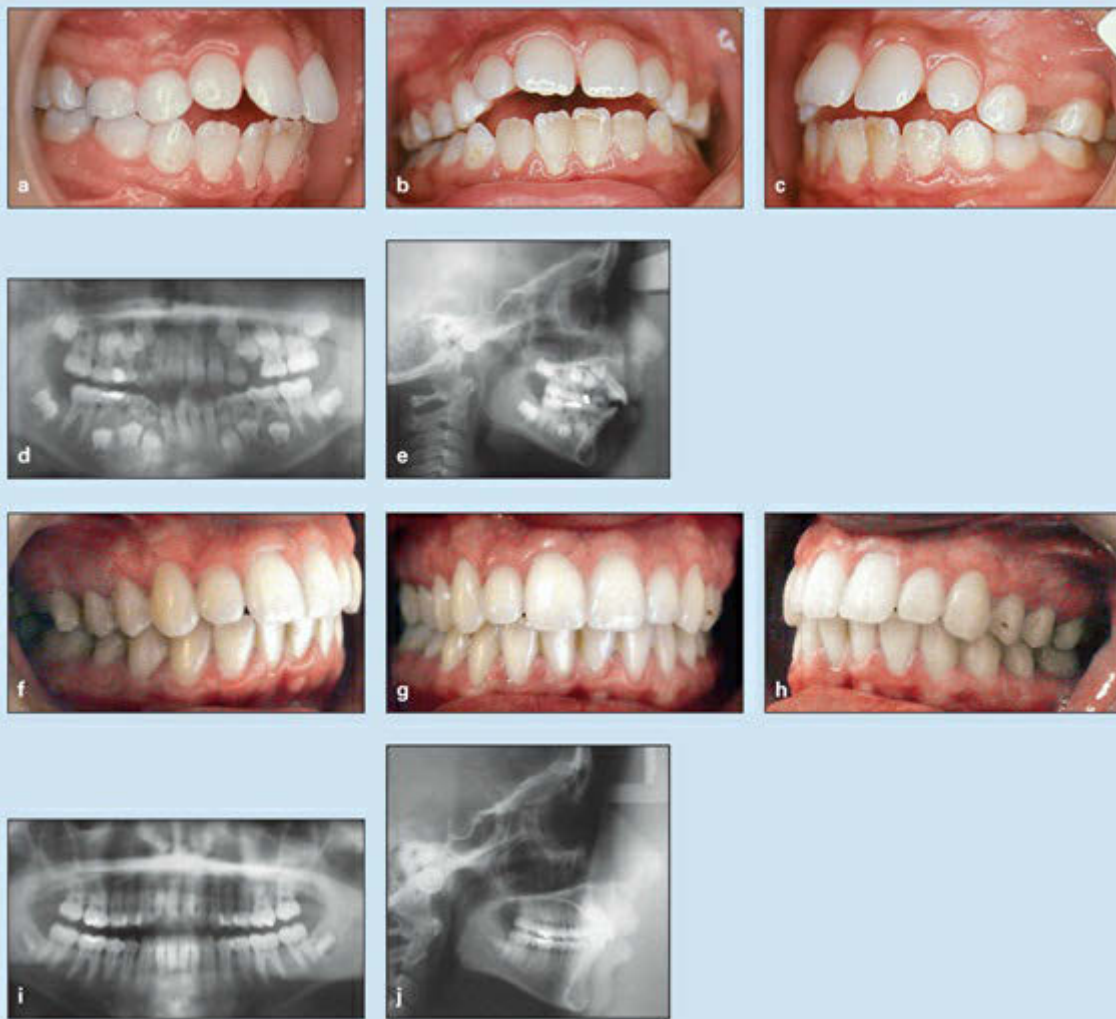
Treatment of a 7-year-old girl who is an active thumb sucker with a developing tongue thrust. She has a dentoskeletal Class I malocclusion, 5-mm overjet, 3-mm dental open bite, and mandibular dental protrusion. (a to c) Pretreatment occlusion. (d) Pretreatment panoramic radiograph. (e) Pretreatment cephalometric radiograph. (f to h) Posttreatment occlusion after retention. (i) Posttreatment panoramic radiograph. (j) Posttreatment cephalometric radiograph.
